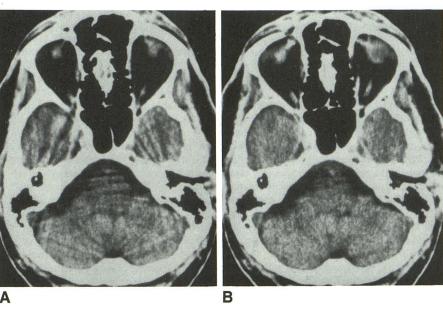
A and B, Contrast-enhanced axial CT images obtained with conventional 8-mm scan (A) and four contiguous 2-mm sections that have been averaged. (Note basilar artery aneurysm in A). Enhancement of choroid plexus (arrow in B) in temporal horns of lateral ventricles can be seen clearly once most of streak artifact has been reduced.
